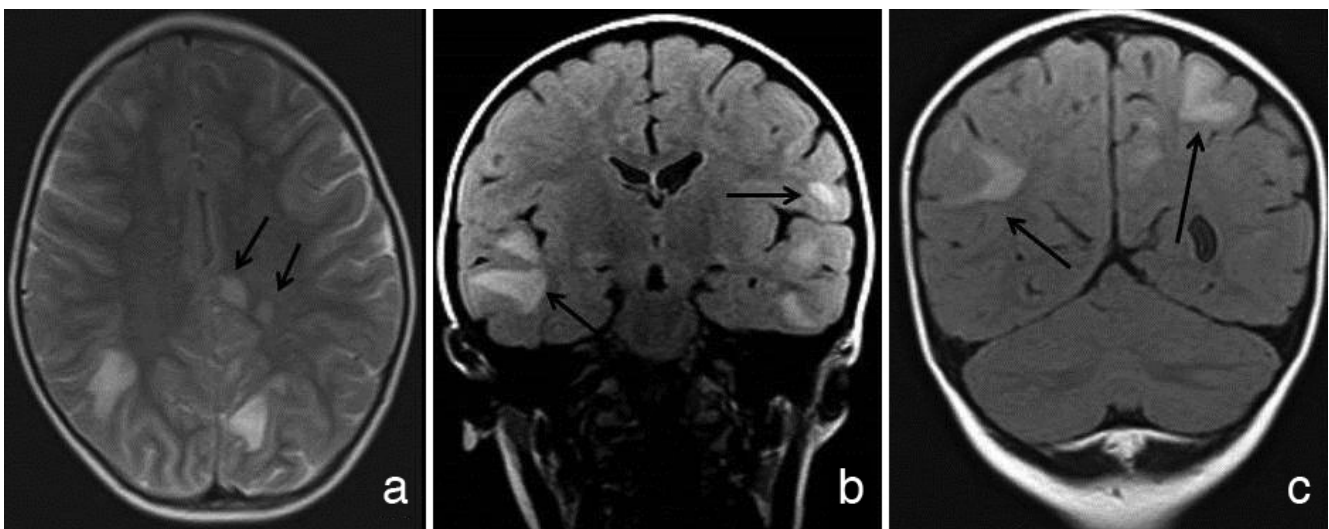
a) T2-weighted axial image shows periventricular profound-localized hyperintense nodules, (b,c) coronal FLAIR images demonstrate subcortical diffuse hyperintense areas in bilateral temporal and frontal lobes
